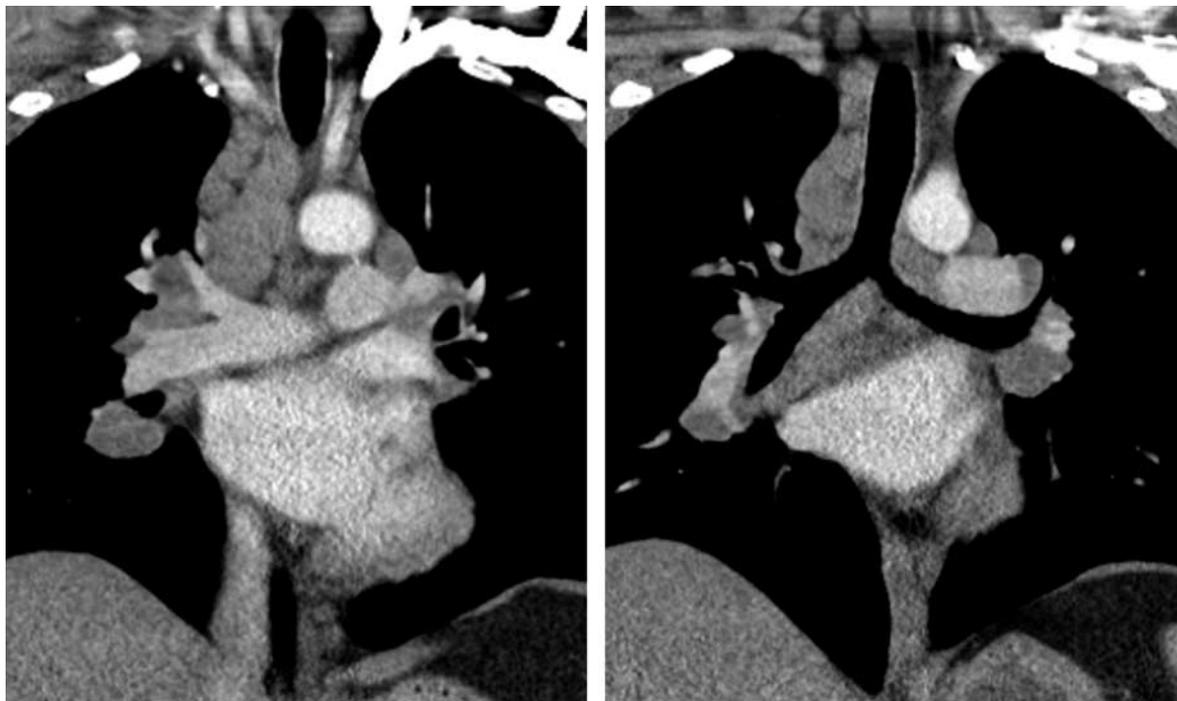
Imaging results of a 44-year-old man with WTC-related sarcoidosis. Coronal 5 mm contrast-enhanced CT images showing typical paratracheal, subcarinal, and hilar lymphadenopathy.
